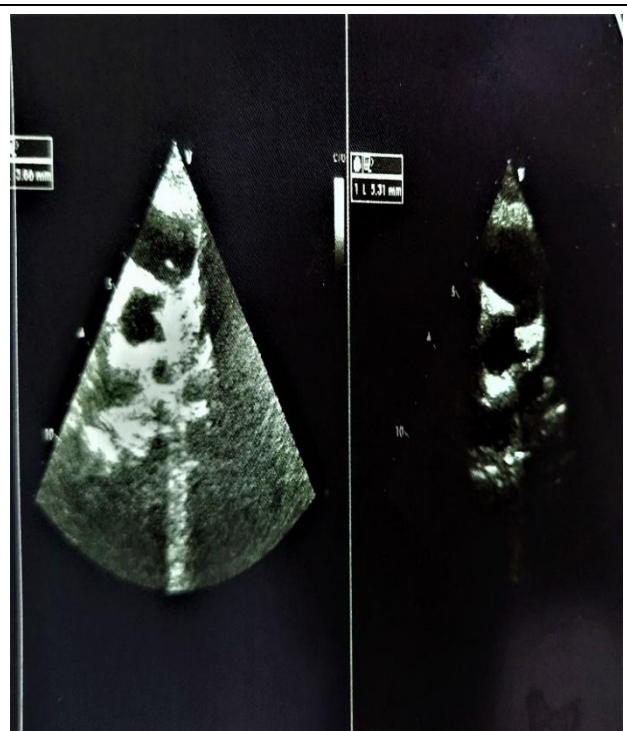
Echocardiograph showing dilated LMCA and LCA.
